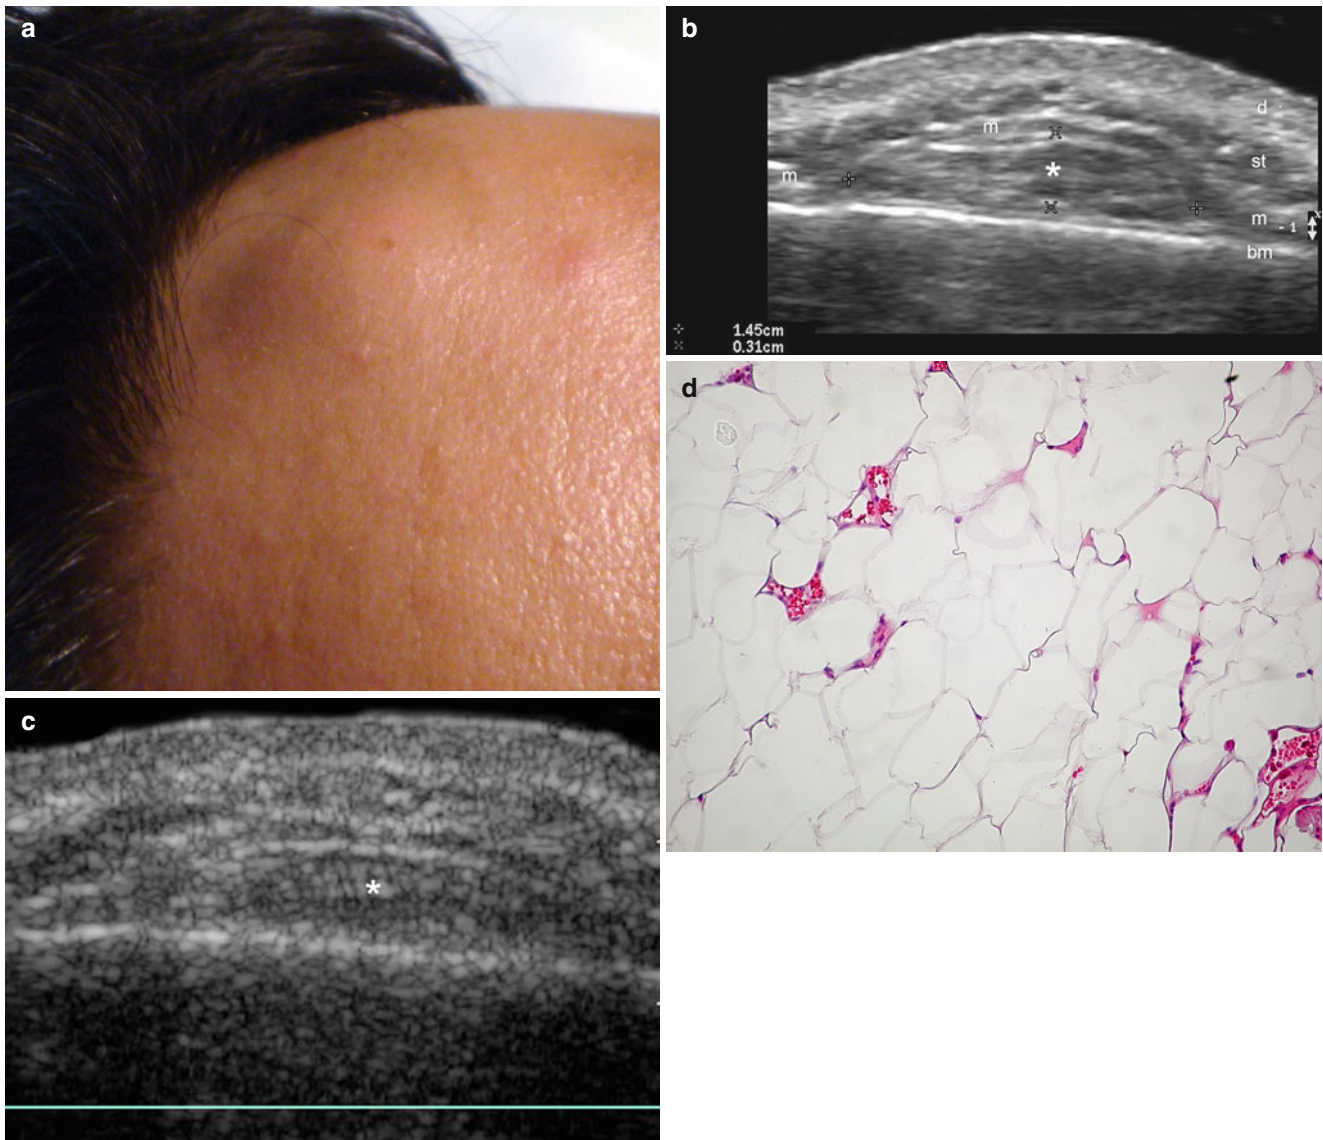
(a–d) Subgaleal lipoma. (a) Clinical image shows skin-colored swelling in the frontal region. (b) Grey scale ultrasound image (transverse view) demonstrates a 1.45×0.31 cm, well-defined, oval-shaped hypoechoic nodule (*) located between the epicranial muscle and the bony margin of the skull. Notice that the muscle is displaced upward. (c)
